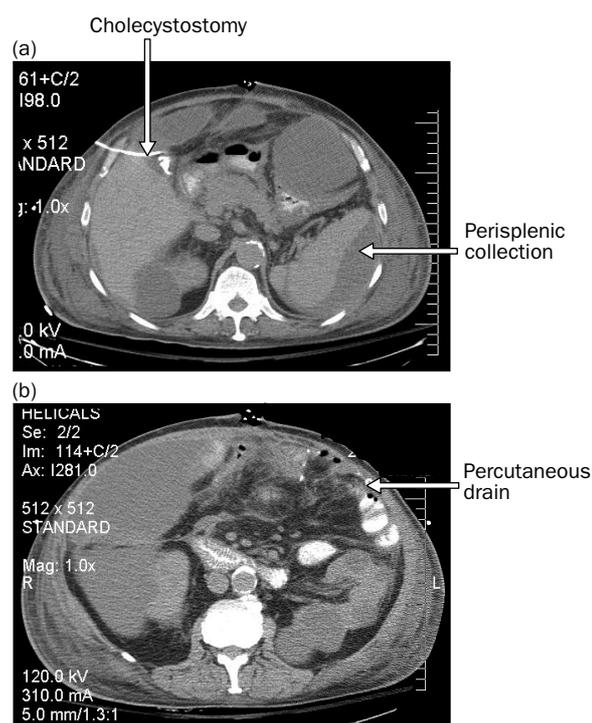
An abdominal CT scan showing (a) percutaneous cholecystostomy tube and perisplenic fluid collection. The latter is homogeneous, without intracavitary air or rim enhancement that might suggest an abscess. (b) After the previous drainage of an intra-abdominal abscess, the CT scan shows no residual cavity or fluid, but marked mesenteric streaking, compatible with persistent inflammation.
